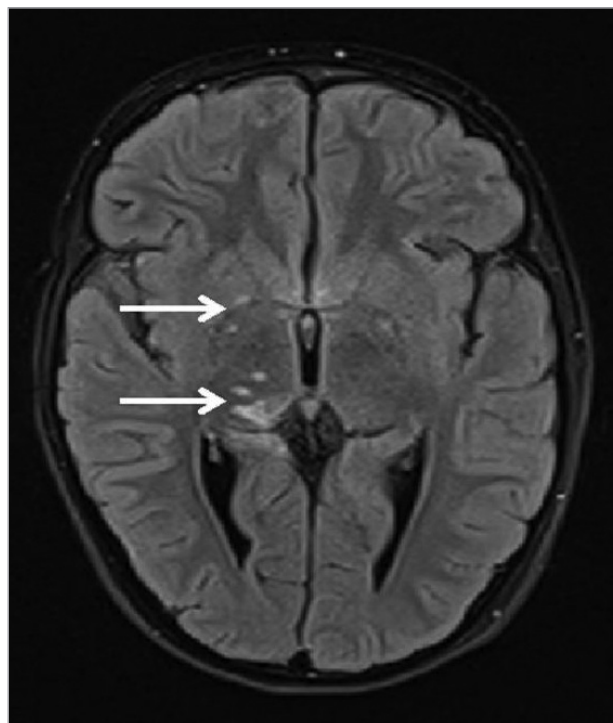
Brain MRI, FLAIR seq. Vasogenic lesions in the right thalamus and lenticular nuclei
